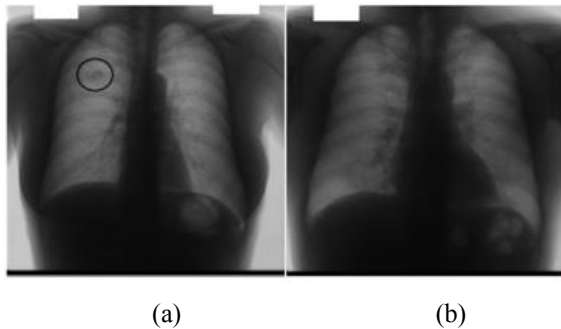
Example of Chest X-ray images from the database. (a) Image with a nodule (b) Image without a nodule.
